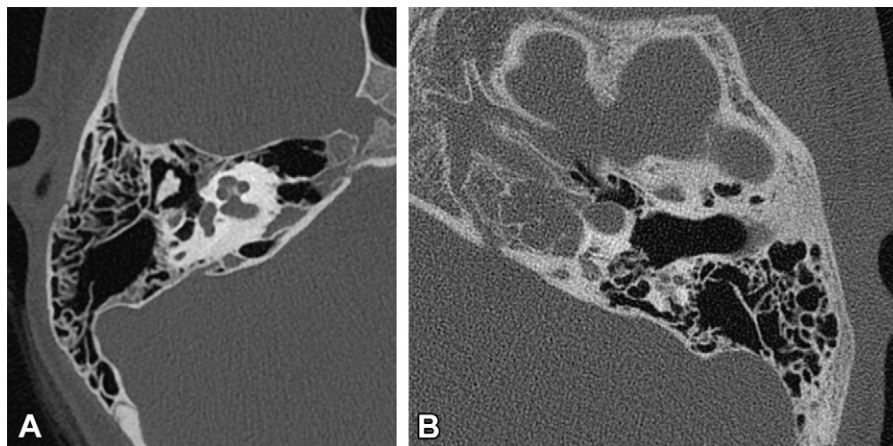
Axial temporal bone CT images demonstrate variations of the petrous apex in two different pediatric patients. (A) Pneumatized petrous apex. (B) Pneumatized petrous apex with opacified air cells due to bland effusion. Note the lack of expansion, intact cortex, and relatively hyperaerated mastoid.
